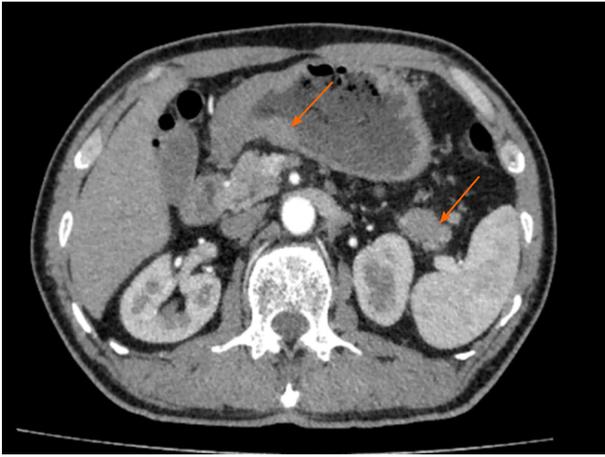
Imaging examinations performed before surgery. On contrast-enhanced computed tomography of stomach, arrow on the left showed uneven thickened with irregular mucosa and heterogeneous contrast enhancement on the antrum of gastric wall; arrow on the right indicated a space-occupying lesion about 34 mm × 16 mm in the tail of the pancreas.
